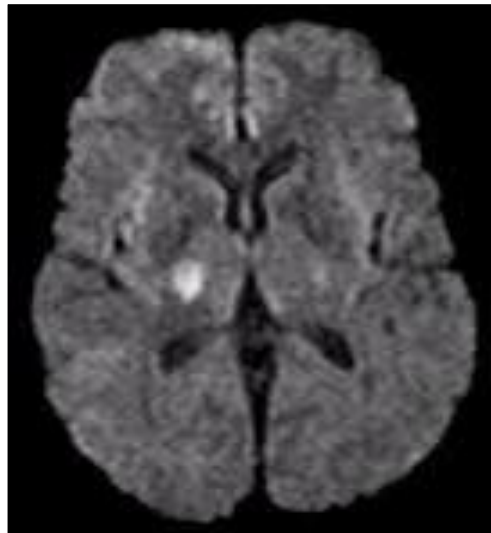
MRI confirming the lacunar stroke in right thalamic region
